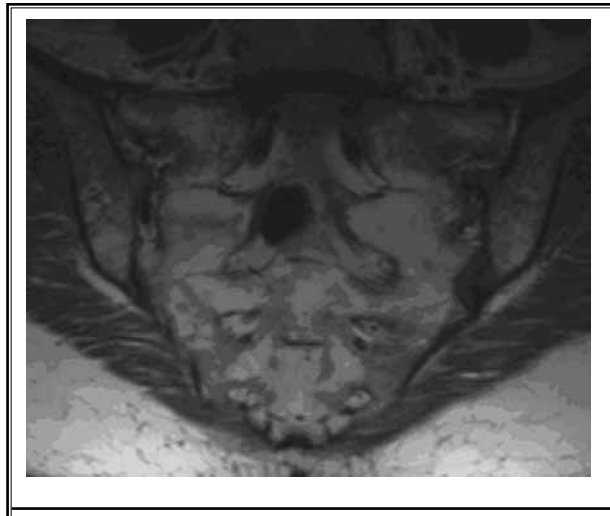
Coronal T1 MRI demonstrating right-sided perineural cyst at S2
